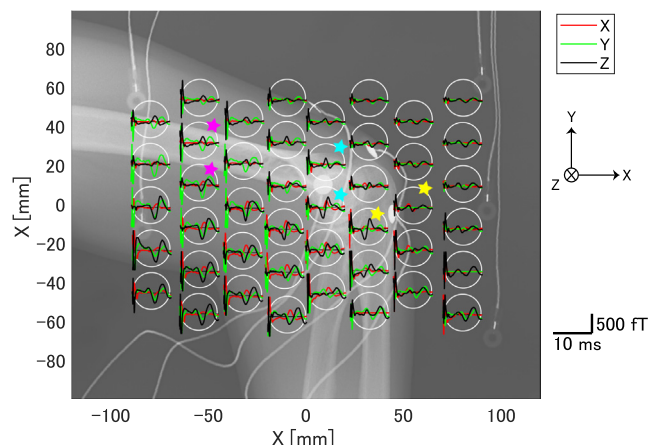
Evoked magnetic fields of a representative case. Evoked magnetic fields recorded from each sensor are superimposed on the X-ray image. White circles represent sensors. Red waveforms show magnetic fields recorded from X coils, with upward positive in the X-axis; green waveforms are from the Y coil, with upward positive in the Y-axis; and black waveforms are from the Z coil, with upward positive in the direction toward the floor. Polarity is reversed between either side of the assumed position of the ulnar nerve (marked with colored stars). (For interpretation of the references to colour in this figure legend, the reader is referred to the web version of this article.)
